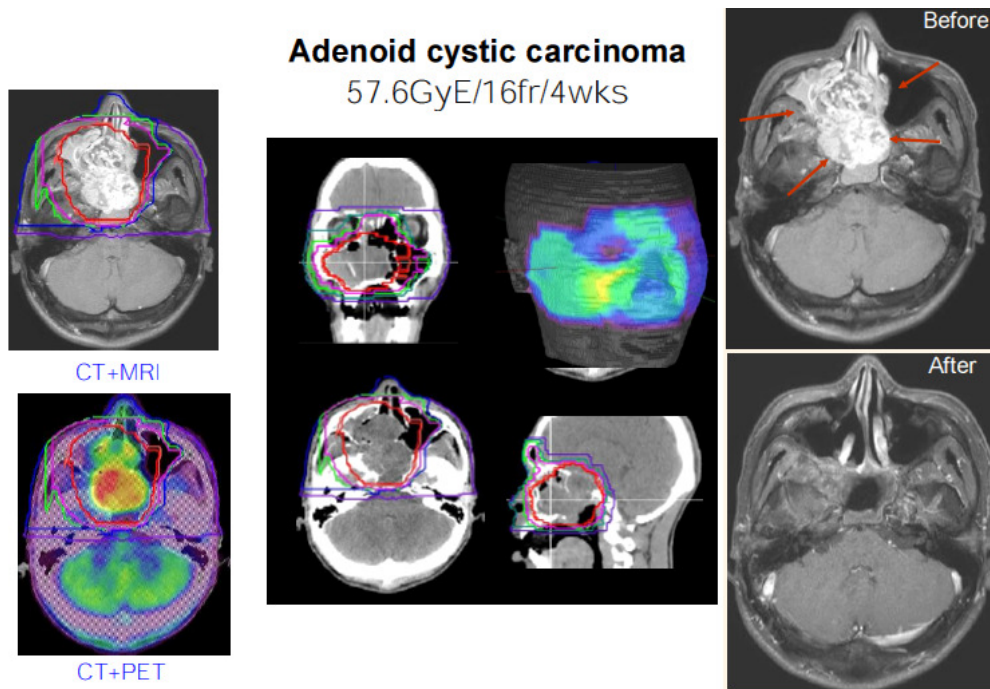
An example is shown of treatment planning for head and neck cancer. Fusion images of CT+MRI and CT+PET are commonly used.
